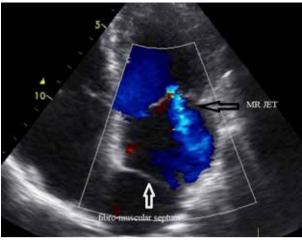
2D echocardiography, showing mitral regurgitation.
